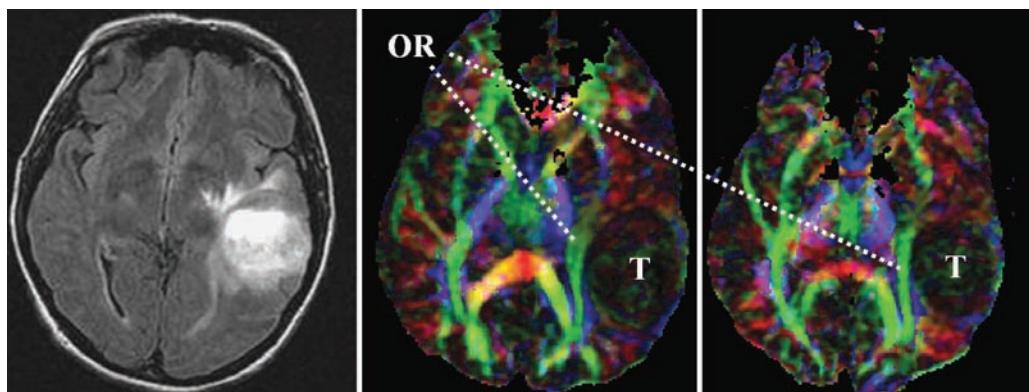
FLAIR image (*left*) and DTI directional maps (*right*) show a left temporal GBM in a 53-year-old female, contacting and medially displacing optic radiation (green in DTI). Despite the lack of proximity of the lesion to striate or extrastriate visual cortex, resection along the medial border of the tumor puts elementary visual function at risk. Abbreviations: GBM, glioblastoma multiforme; DTI, diffusion tensor imaging; FLAIR, fluid attenuated inversion recovery; OR, optic radiation; T, tumor.
